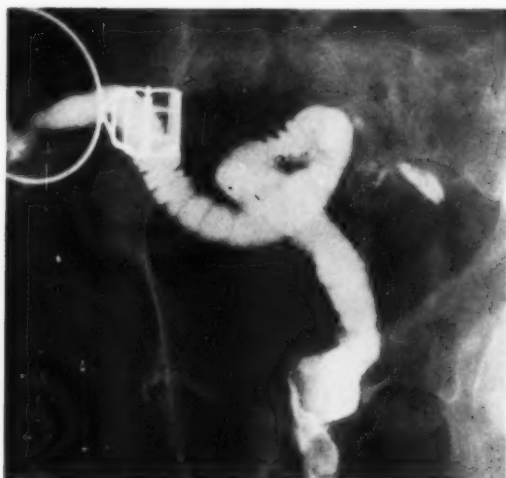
X-ray showing a fully healed ileo-rectal anastomosis. A previous barium enema had demonstrated a leak through the anastomotic line and the barium that had escaped is still present in the pelvis.
